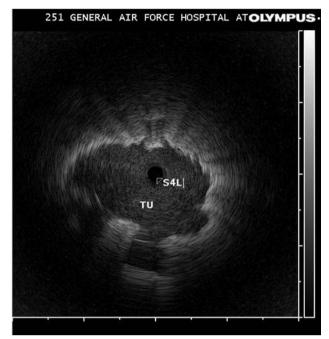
Ultrasonographic image using a 20-MHz radial probe of adenocarcinoma at S4L. TU: Tumor.
